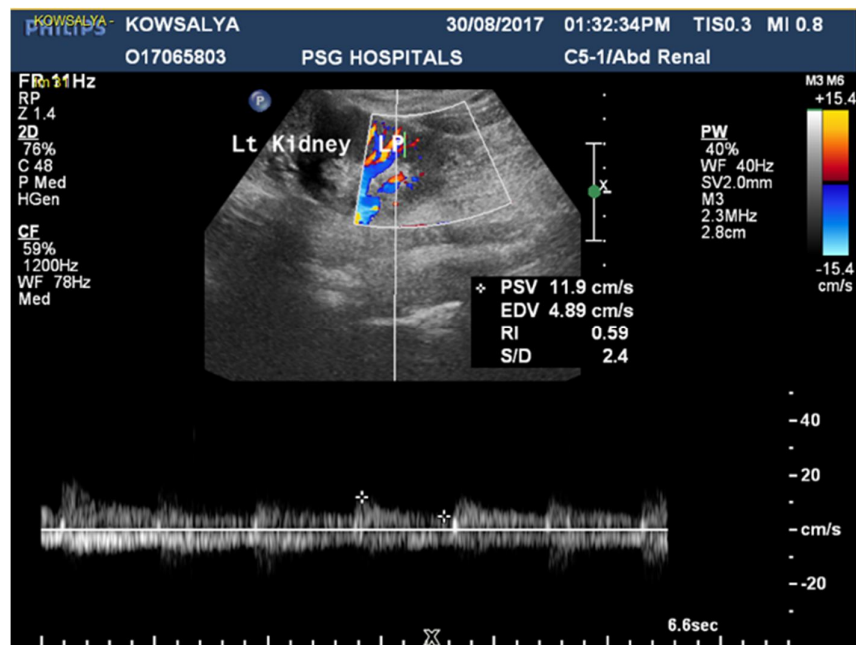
(E) Doppler US demonstrating an RI value of 0.59 in the lower pole of left kidney (unobstructed).
